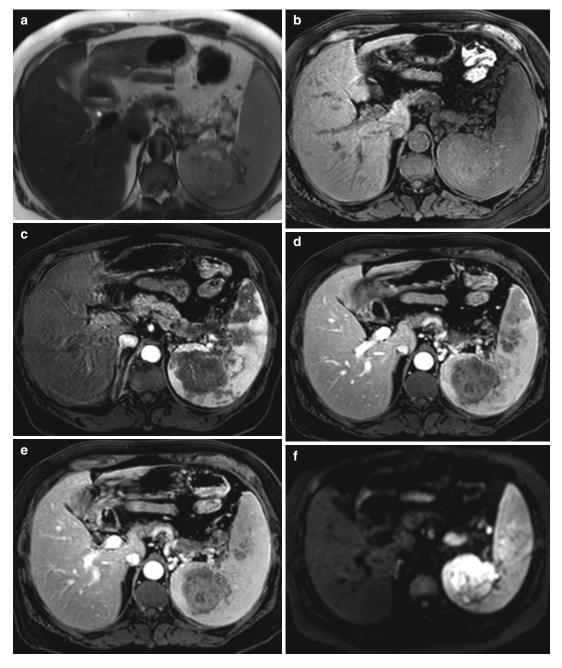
Focal splenic lesion in patient with gastric carcinoma. Axial T2-weighted image demonstrates heterogeneous appearance of a splenic mass (\mathbf{a}) , which is also slightly hyperintense on precontrast fat-suppressed T1-weighted gradient-recalled echo image (\mathbf{b}) . On the dynamic series, the lesion is hypovascular on immediate
